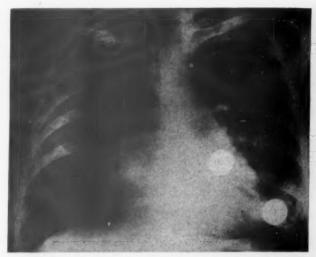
Chest roentgenogram of patient J. P. with tricuspid and mitral stenoses. Right atrium is moderately enlarged. Outline of large left atrium is seen within cardiac shadow. Lower, lateral, white spot is shadow of coin attached to patient at site of mitral diastolic murmur and thrill; upper, medial spot marks site of tricuspid murmur and thrill.
